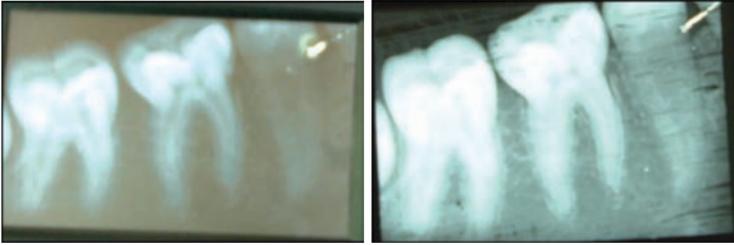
Photograph showing lightening a dark radiograph by removing the emulsion one side of the film
